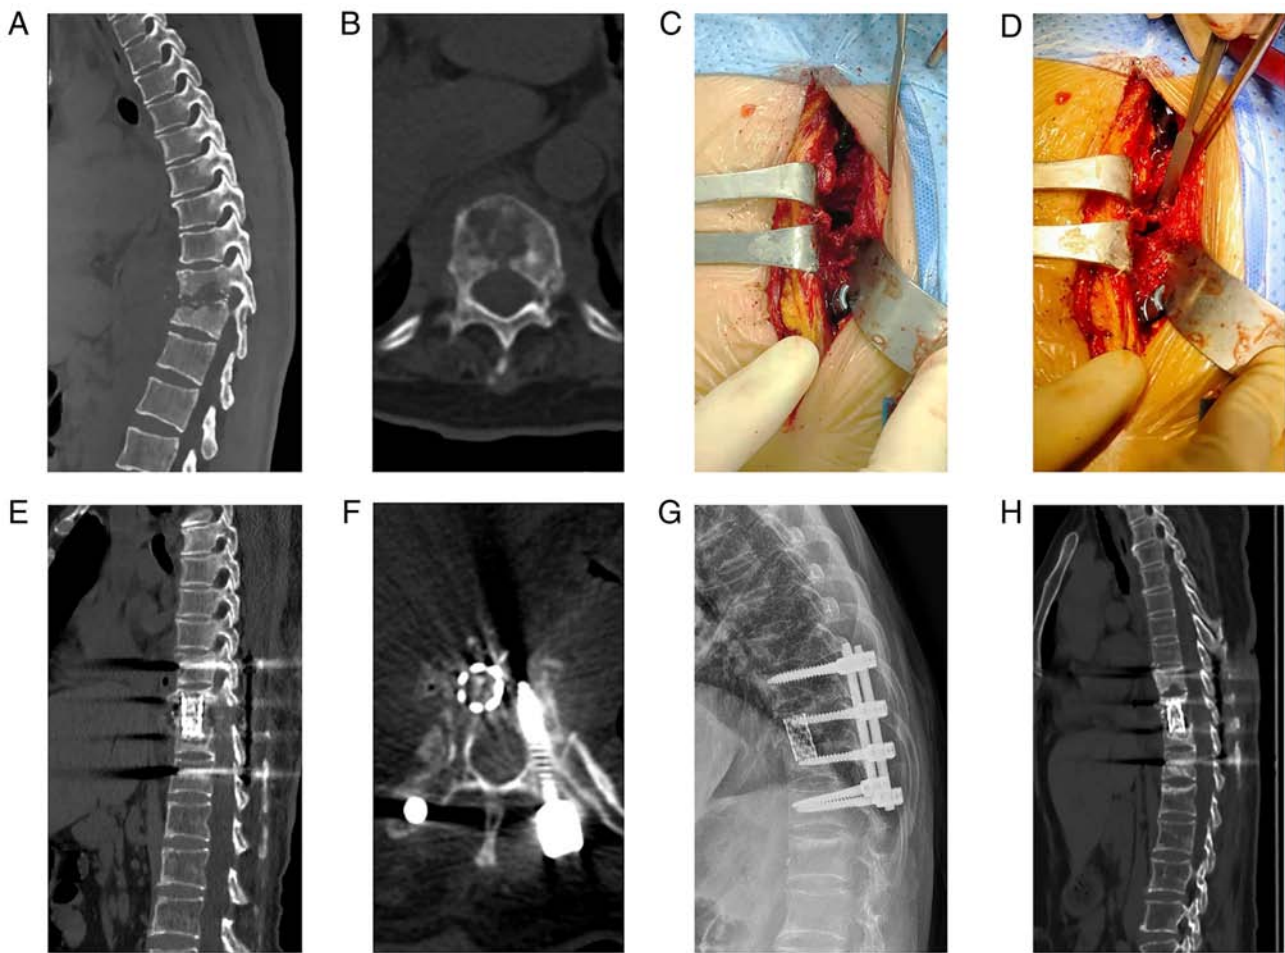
Images of a 75-year-old patient with T9/10 lesions who underwent surgery using the Wiltse TTIF approach. (A) Sagittal and (B) coronal pre-operative imaging reveals severe spinal cord compression and destruction of the T9/10 vertebrae. (C and D) Images captured during the Wiltse TTIF surgery. Kyphosis correction is evident on the postoperative (E) sagittal and (F) coronal CT scans. (G) X-ray at the third month following surgery reveals good bone fusion and no obvious loss of kyphosis correction. (H) Sagittal CT scan at 9 months after surgery demonstrates satisfactory graft fusion without spinal tuberculosis relapse. TTIF, transforaminal thoracic interbody fusion; CT, computed tomography.
